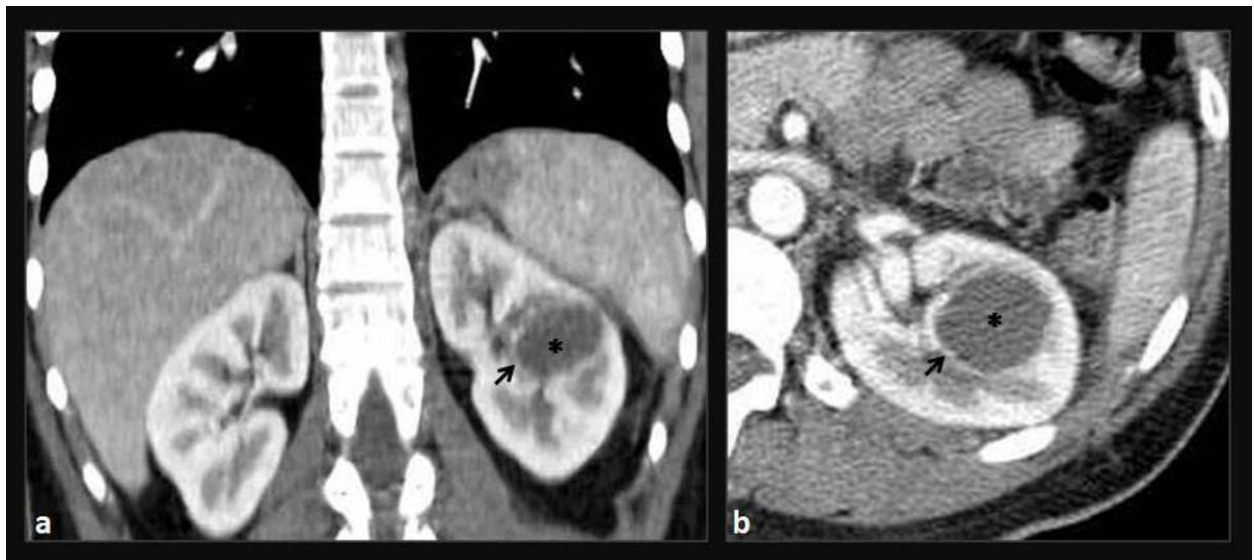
Renal abscess (same case as in fig.9). Coronal (a) and axial (b) contrast-enhanced CT images show a round low-attenuation collection (*) with enhancing walls (arrows), in the mid pole of the left kidney.
